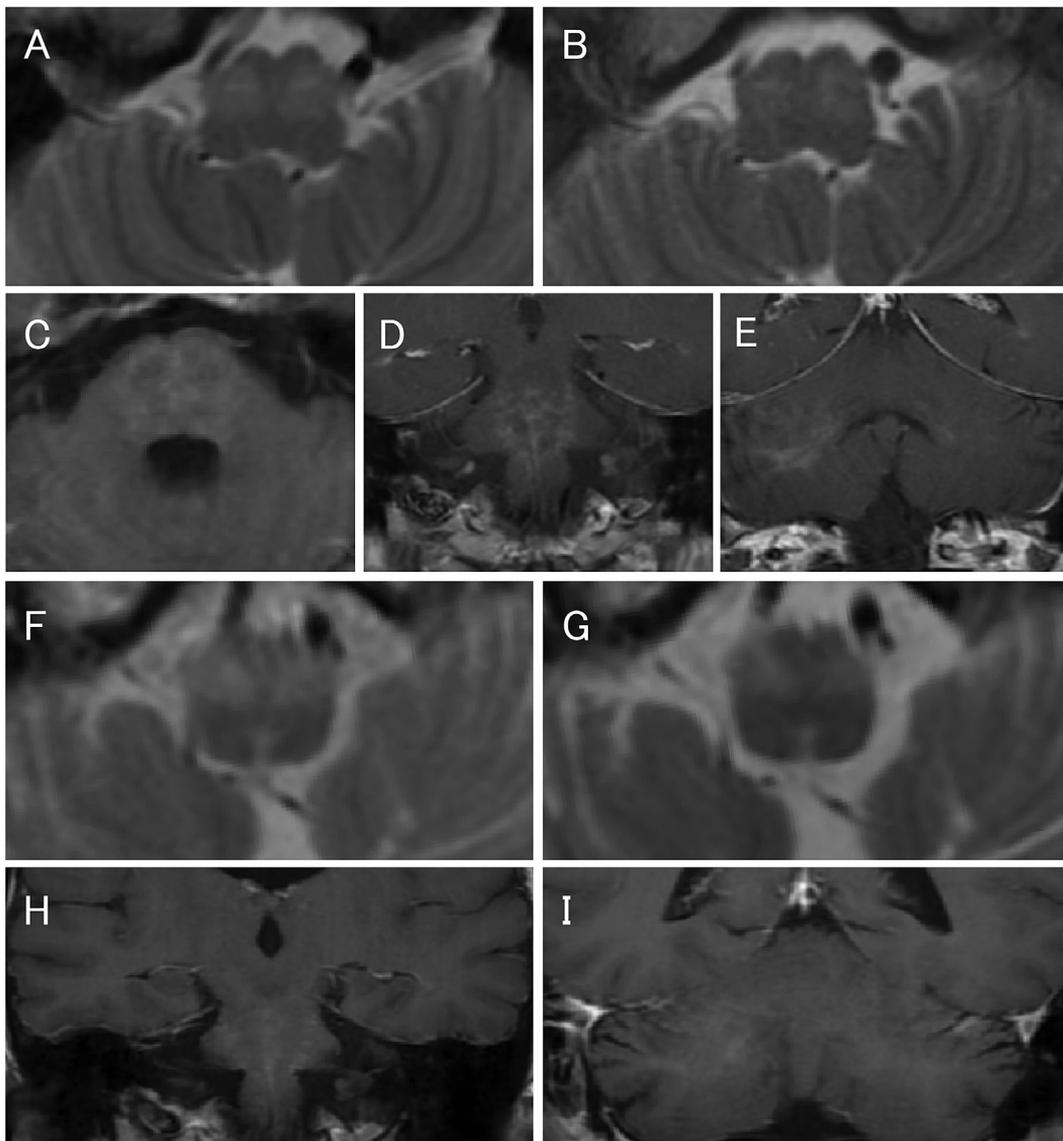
Brain MRI scans of patients with OH (case 1: A–B and case 2: C–I). A: Axial T2-weighted magnetic resonance images obtained at admission showed enlargement and increased signal intensities of bilateral inferior olives. B: Axial T2-weighted images 2 weeks after the treatment showed improvement of OH. C–E: Contrast-enhanced T1-weighted images obtained on admission showed punctate enhancement affecting the middle cerebellar peduncle, pons and cerebellum. F: First MRI study showed enlargement and increased signal intensities of bilateral inferior olives. G: Follow-up MRI 10 months after steroid administration showed reduction of the enlargement of olives, but signal intensities were not altered. H, I: Contrast-enhanced T1-weighted images obtained two weeks after the treatment revealed diminished enhanced lesions in the pons and the cerebellum.
